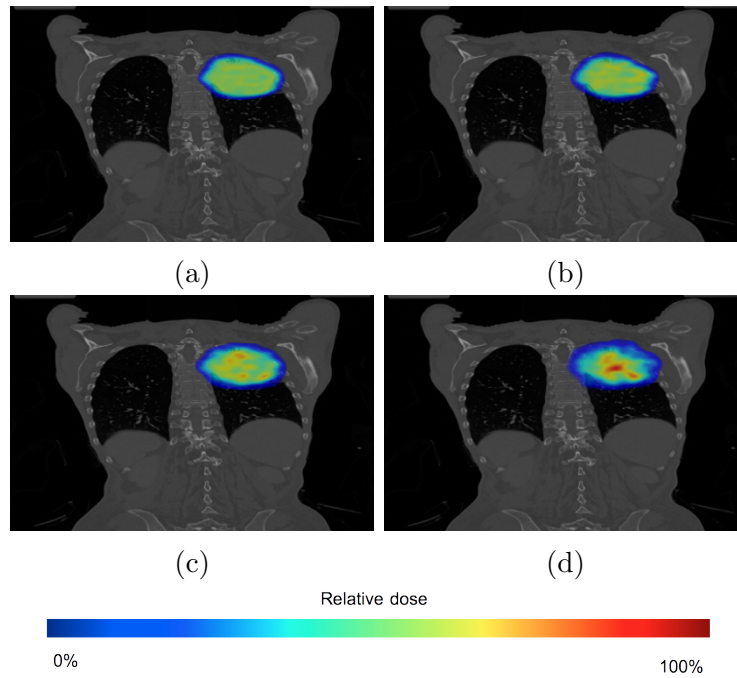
Dose distributions computed overlaying a patient CT image (coronal planes), for a moving patient with compensation for different monitoring accuracy: $\sigma_\delta = 0$ cm (5.19a), 0.3 cm (5.19b), 0.75 cm (5.19c), 1.5 cm (5.19d).
